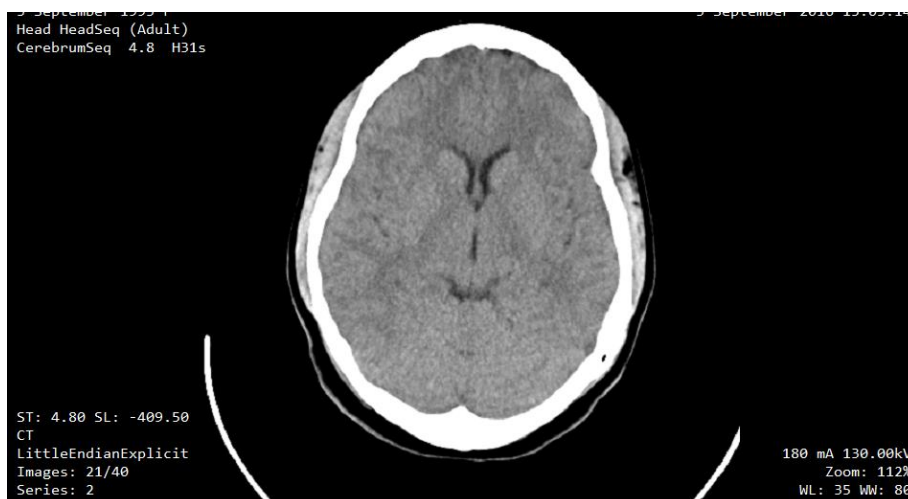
A slice of the unoptimized CT image at 180mA and 130kV
